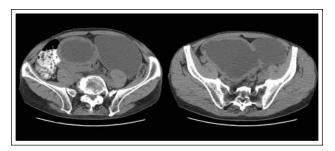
Non-contrast computed tomography scan of the abdomen and pelvis demonstrating the large size and neck of the diverticulum. Also demonstrated is a thickened bladder wall.
